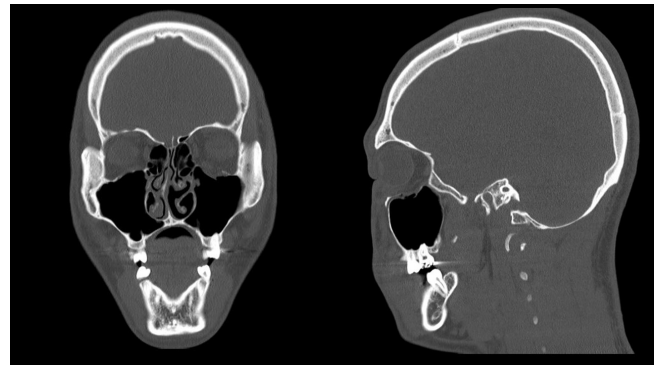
Initial CT (PTD 0) showing a mild displaced orbital floor fracture.
